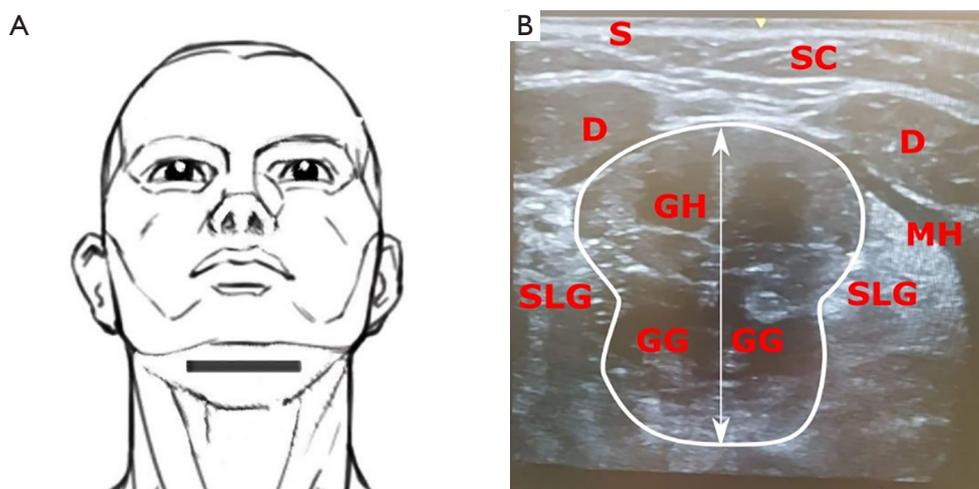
Coronal view. (A) positioning of the transducer in the submental area (coronal plane), (B) ultrasound scan in the coronal plane showing the following structures: skin (S), subcutaneous tissue (SC), anterior bellies of digastric muscles bilaterally (D), mylohyoid (MH), geniohyoid (GH), genioglossus (GG) and sublingual glands (SLG) on both sides. The distance of the upper margin of the GH to the lower border of the GG represents the tongue base thickness (white arrow) and the surrounding (white outline) represent the cross-sectional area (CSA).
